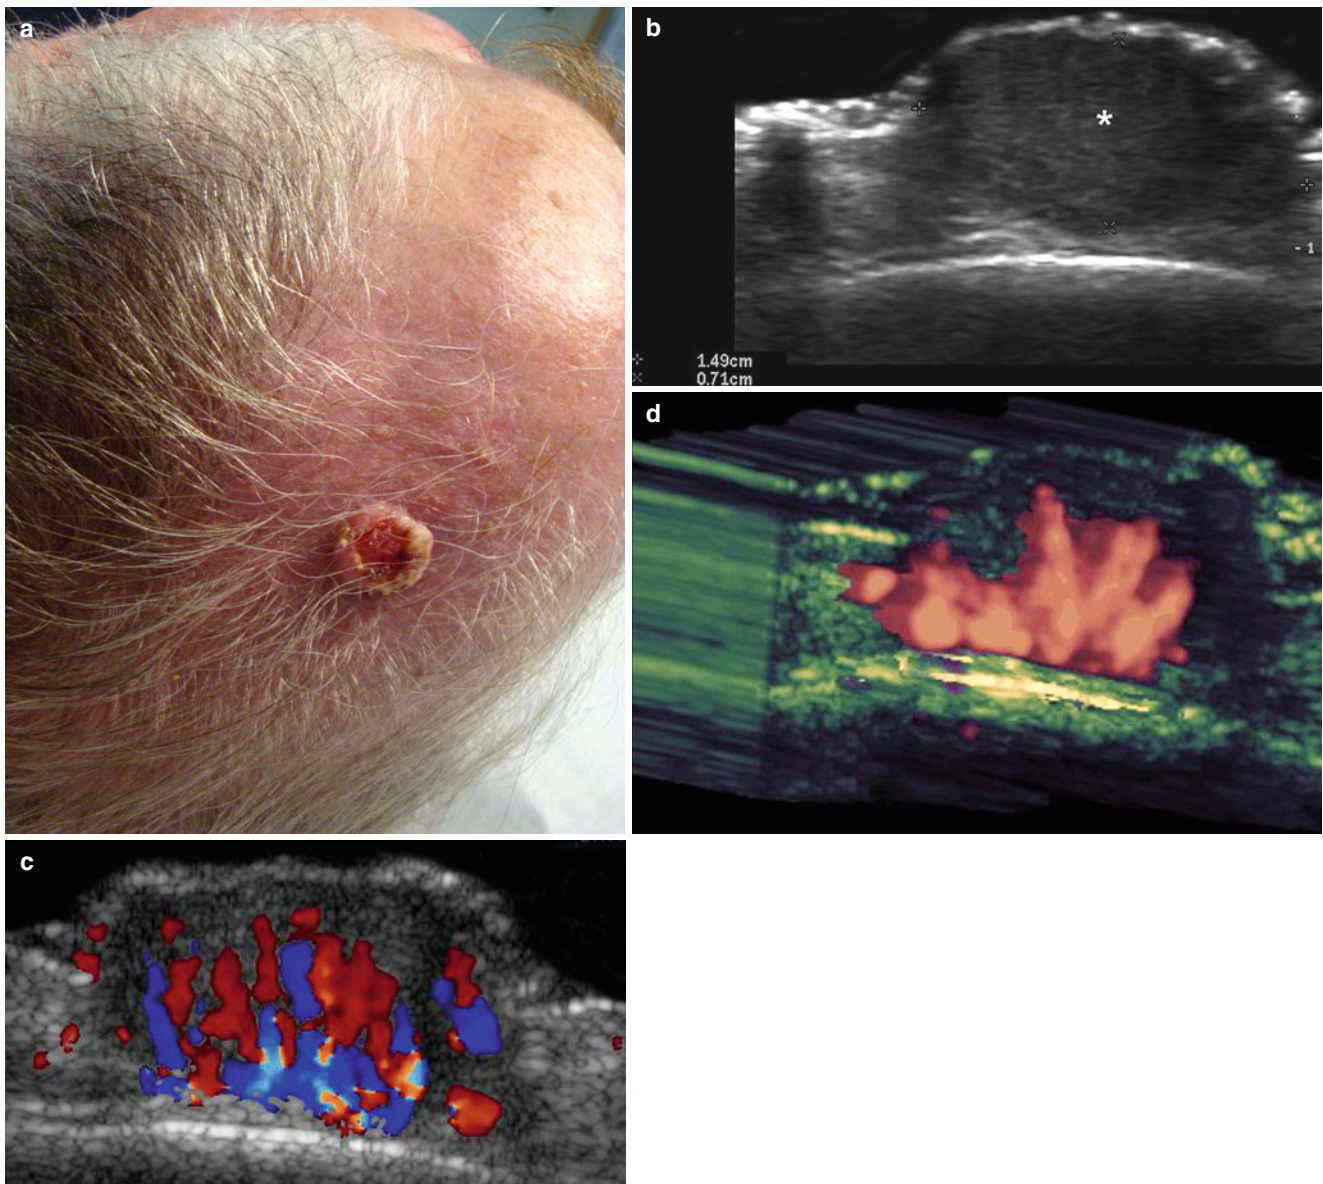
(a–d) Squamous cell carcinoma. (a) Clinical image demonstrates erythematous and ulcerated lump in the left parietal region of the scalp. (b) Grey scale ultrasound image (transverse view) shows a 1.49 cm (transverse) × 0.71 (depth) well-defined hypoechoic solid mass
